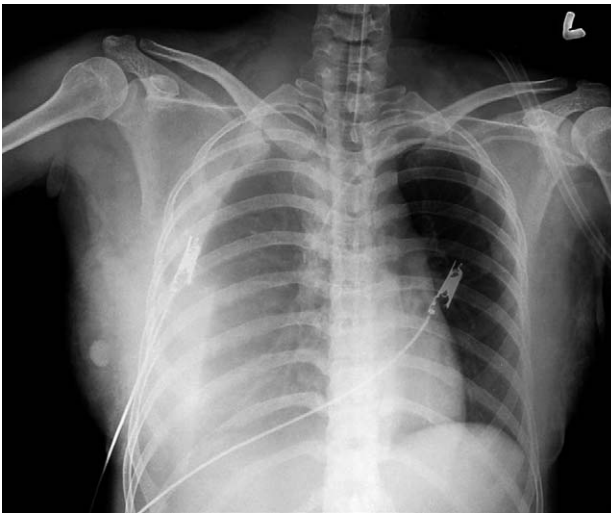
Chest posterior to anterior radiography showed hemothorax on the right lung.
